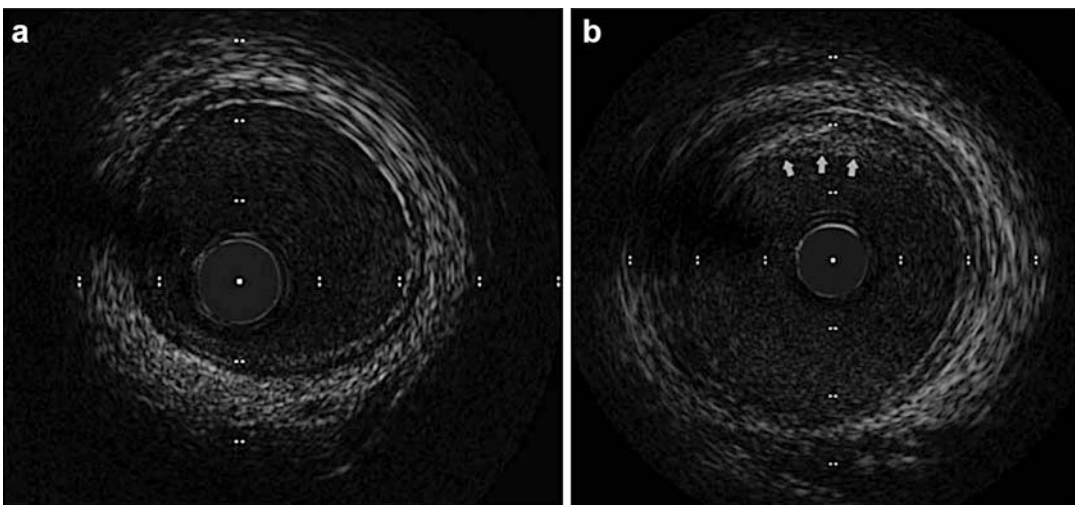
Intravascular ultrasound (IVUS) images of (a) a normal coronary artery and (b) a coronary artery demonstrating allograft vasculopathy with intimal
